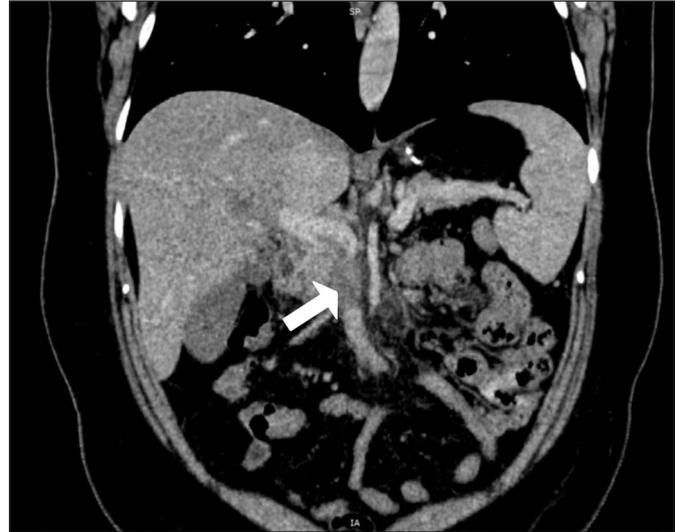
Coronal CT sections of SMV and main portal venous thrombosis (arrow).
